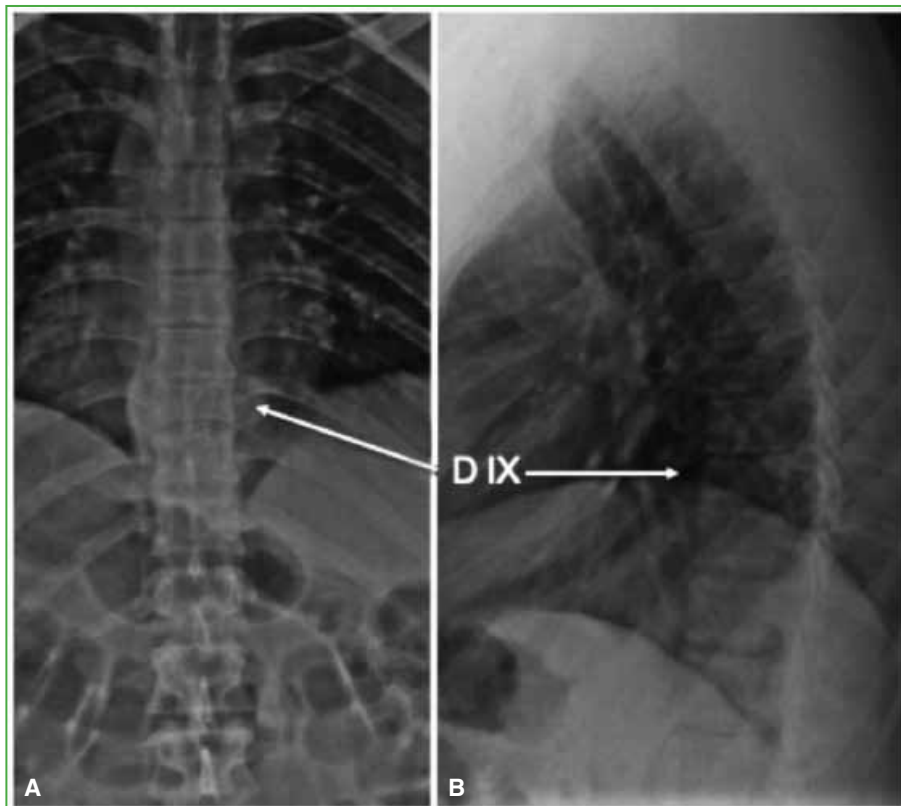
Case 1. A 22-year-old man. Anteroposterior (A) and lateral (B) radiographs of the thoracic spine. An alteration in the bone tissue at the T9 level and a slight collapse of the vertebral body are observed.
